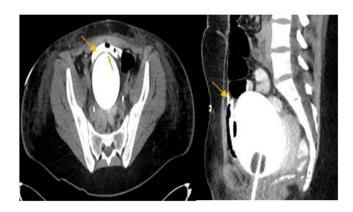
Delayed contrast CT scan demonstrating contrast leak (indicated by the yellow arrow) from the wall of the urinary bladder
